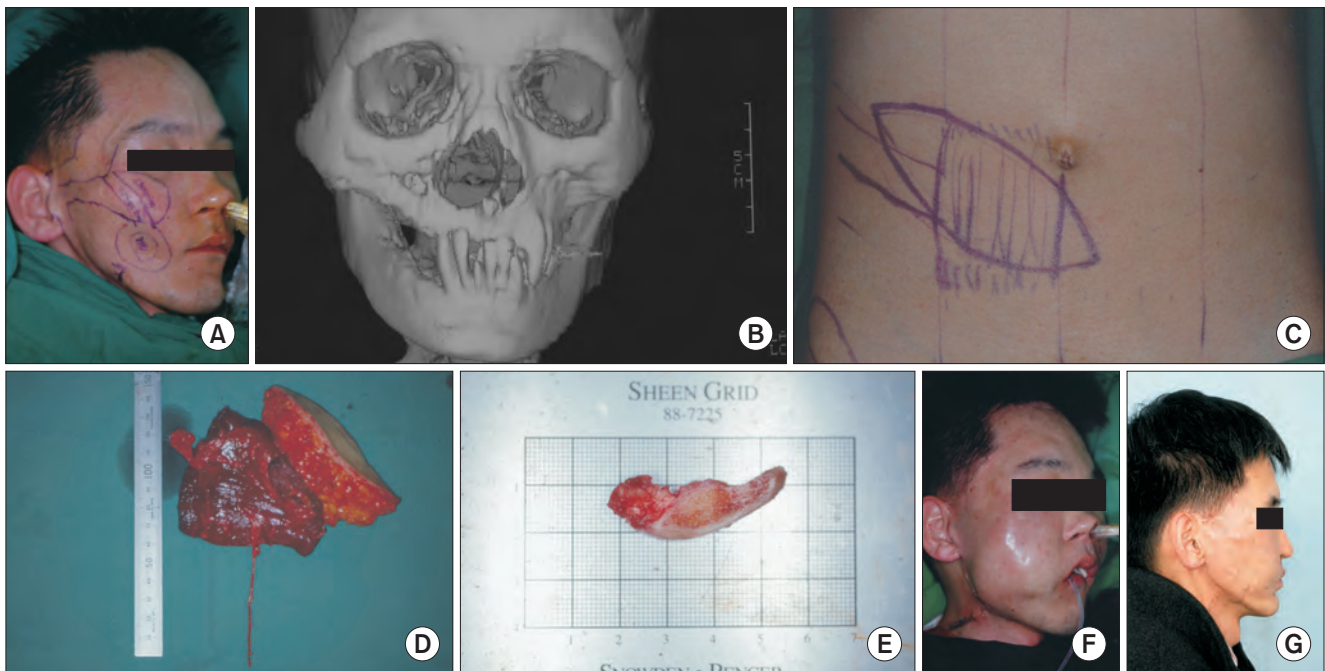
(A) Preoperative picture of postradiation deformity on the right cheek. The patient sustained protruding zygomatic arch, and depressed cheek with severe facial asymmetry after excision of nasopharyngeal cancer and postoperative radiation therapy. Partial ostectomy of zygoma, and filling the depressed cheek using muscular components of a free rectus abdominis musculocutaneous (RAM) chimeric flap was planned. The facial artery was marked as a recipient artery. (B) Preoperative three-dimensional computed tomography. Protruding zygomatic arch was observed. Therefore, reduction malarplasty with partial ostectomy of zygoma was planned. (C) Design of donor site. Skin island was designed as an oblique fashion for coverage of introral defect, and vertical rectus abdominis muscle flap for filling the depressed cheek volume. (D) After elevation of free RAM chimeric flap. The chimeric flap consists of muscular component and skin paddle. (E) After partial ostectomy of zygoma. (F) Immediate postoperative picture. The contour of temple to chin was restored. (G) Four years after reconstruction with a free RAM flap with reduction malar plasty with partial ostectomy and release of scar contracture.
